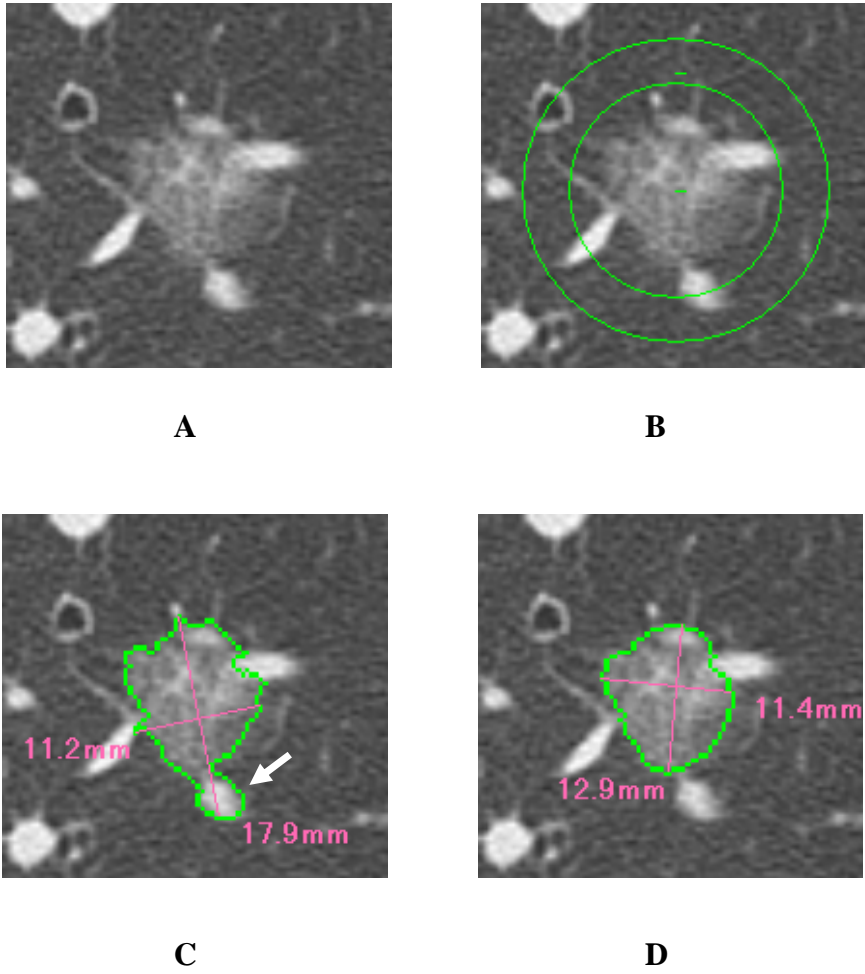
Example of nodule volumetry on thin-section helical CT images.
